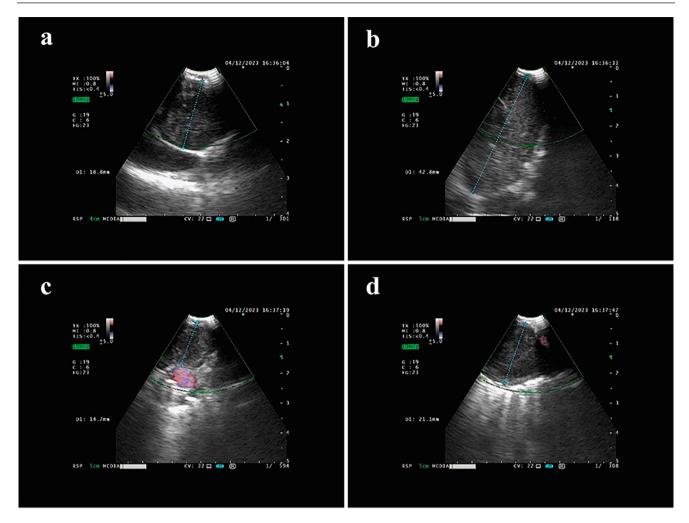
Endobronchial ultrasound is revealing lymph node soft tissue shadows in groups 4R (a), 7 (b), 11R (c), 12R (d), with maximum long diameters of approximately 18.8 mm, 42.8 mm, 14.7 mm, and 21.1 mm, respectively
